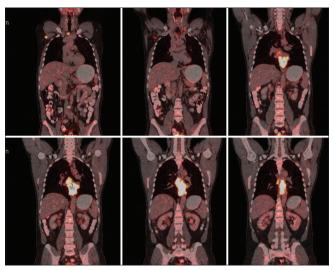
A positron emission tomography computed tomography done for staging revealed an irregular bulky growth in the middle third of the esophagus (SUV: 15.9) with involvement of the adjacent mediastinal pleura. In addition, significant adenopathy was noted in the subcarinal regions, right para-tracheal region, (SUV: 3.9) left supraclavicular region (SUV: 1.9), and the right axilla. (SUV: 4.9)
